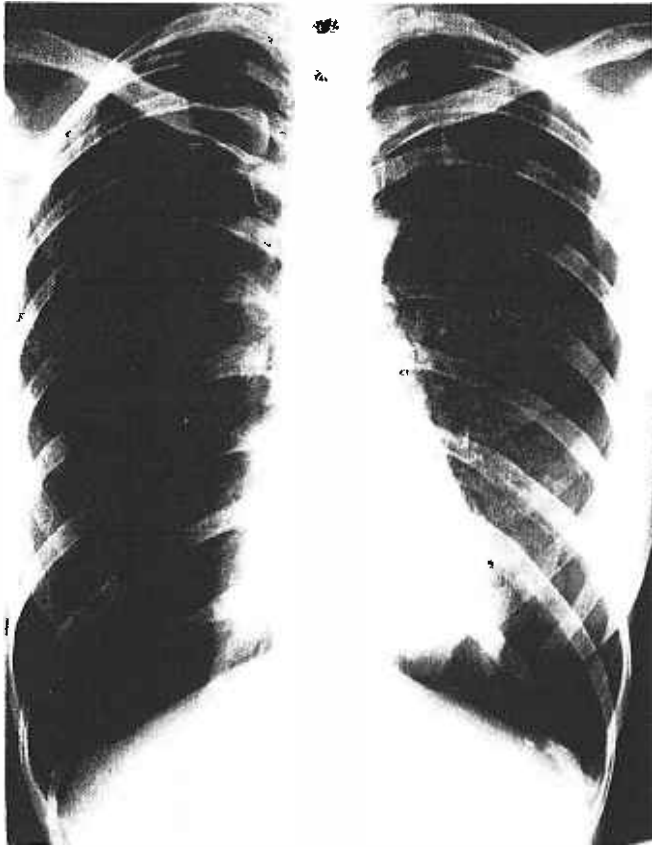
Initial chest radiograph showing bilateral pneumothorax.
